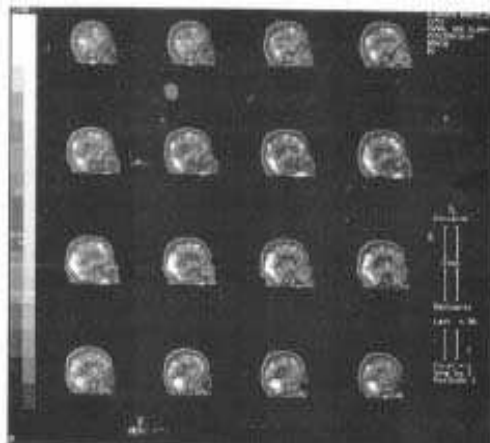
Sagittal view of the brain, normal cerebral SPECT scan.
